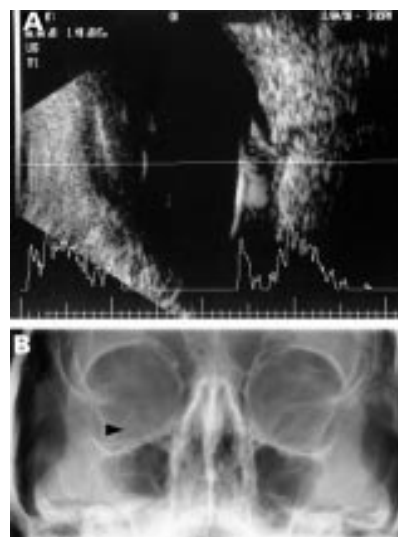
(A) Ultrasound of the right eye showing a linear reflection in vitreous. (B) A plain x ray showing the intraocular hypodermic needle.
